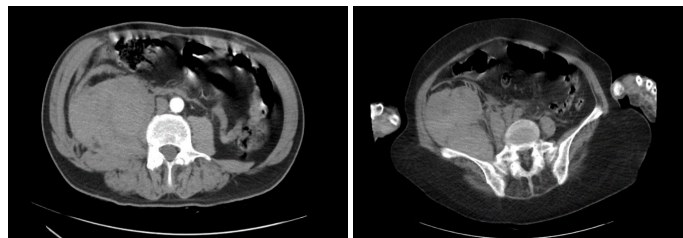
A 77-year-old woman; hematoma in the right retroperitoneal space was demonstrated in both abdominal and pelvic CT scans
